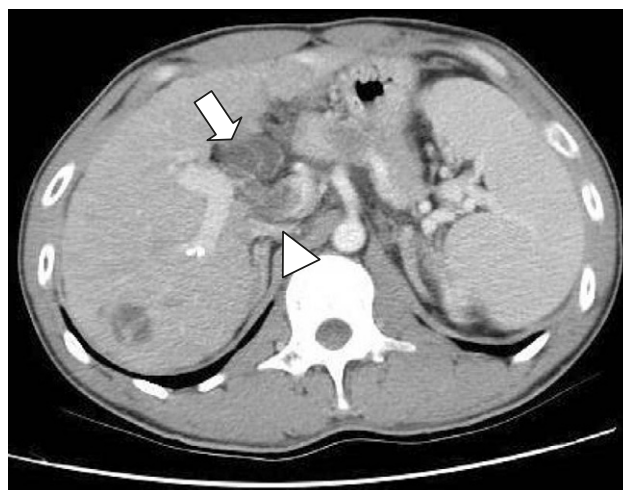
Contrast-enhanced computed tomography in this slice showed peripancreatic fluid collection (arrow) around the pancreatic head and thrombosis of the main portal trunk (arrowhead) that was not detected by magnetic resonance imaging performed 1 month previously. This slice also showed deposition of lipiodol in segments 3 and 6, a suspected dysplastic nodule in segment 6, liver cirrhosis with splenomegaly and collateral circulation at the splenic hilum and perigastric region.
